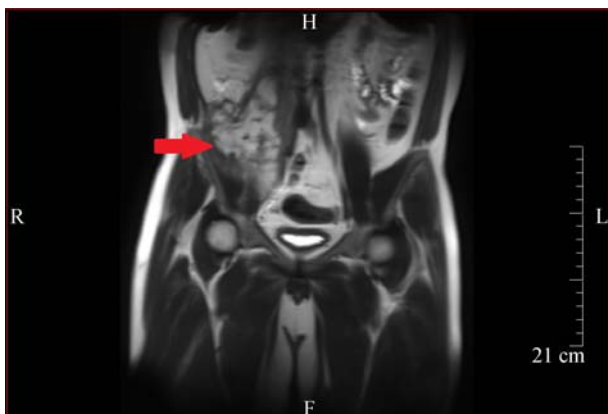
MRI demonstrates a 19 cm × 3 cm × 7 cm fluid collection (arrow) extending along the right psoas muscle with extension into the upper right iliacus muscle
